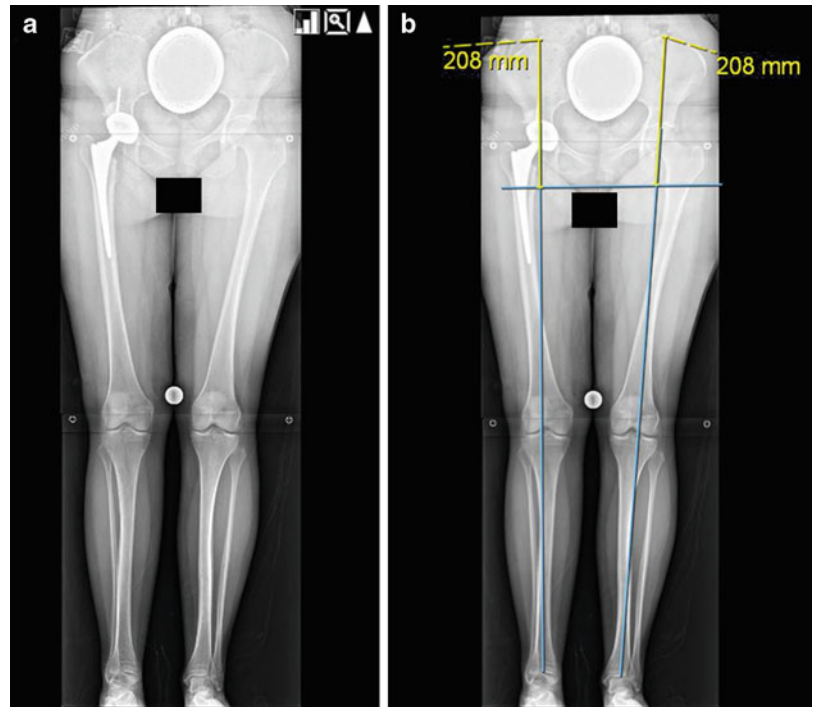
(a–b) Postoperative 51-inch-long erect radiographs of the hip to the ankle demonstrate complete restoration of limb length equality and complete resolution of perceived LLD 1 year after THR. The patient had no apparent LLD and did not need any shoe lifts postoperatively. This is likely due to the patient’s young age and the complete reducibility of the POACH without any structural bony changes that allowed full correction with the soft-tissue releases and THR
